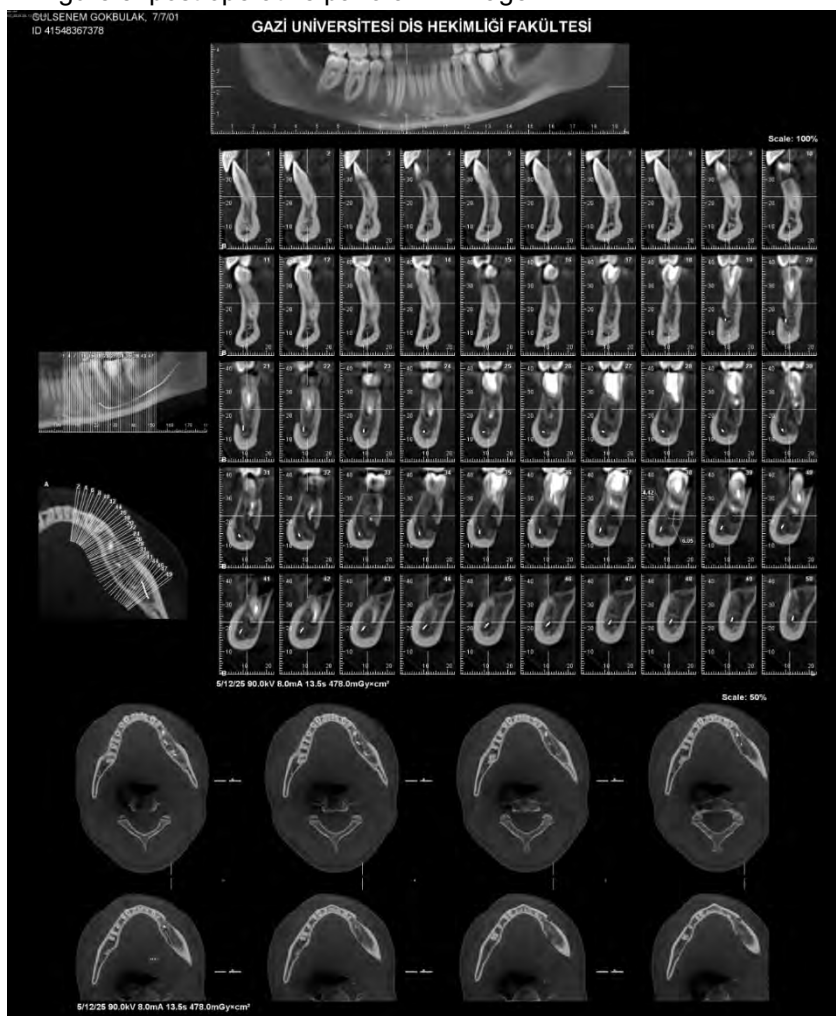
post operative sixth month CBCT image
